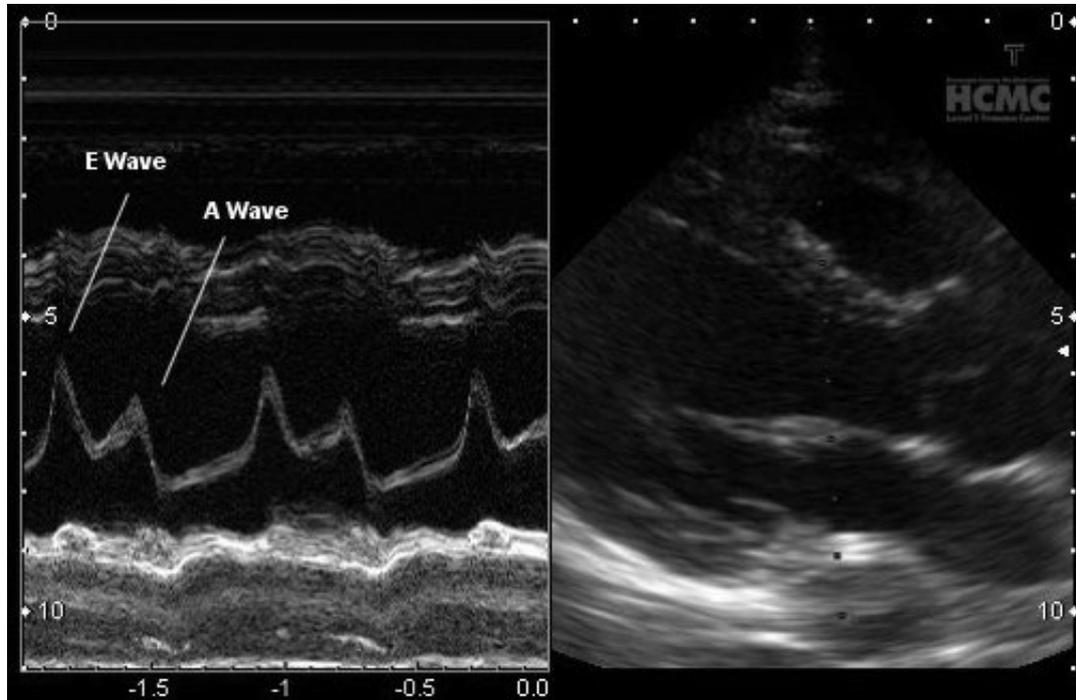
Echocardiographic M-mode image of E-A wave peaks of mitral valve and long-axis parasternal view of the heart.
